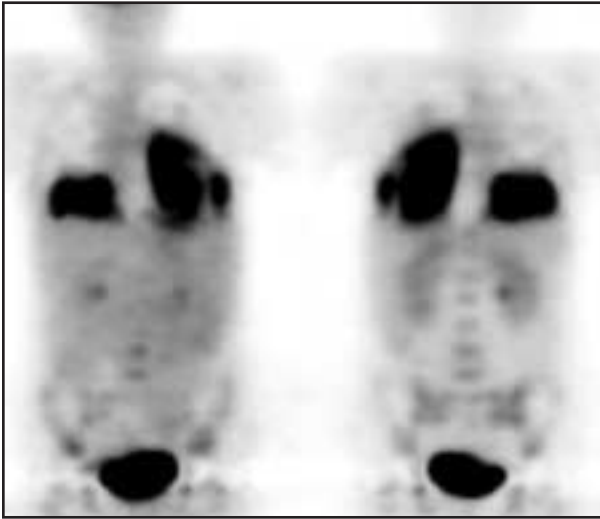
52-year-old woman with history of hairy cell leukemia presented with spiking fevers but no localizing signs. Chest x-ray was reported as showing only small pleural effusions. MIP image demonstrates intense bilateral lower lung FDG accumulation. Bronchoscopy confirmed presence of acute pulmonary inflammation.
